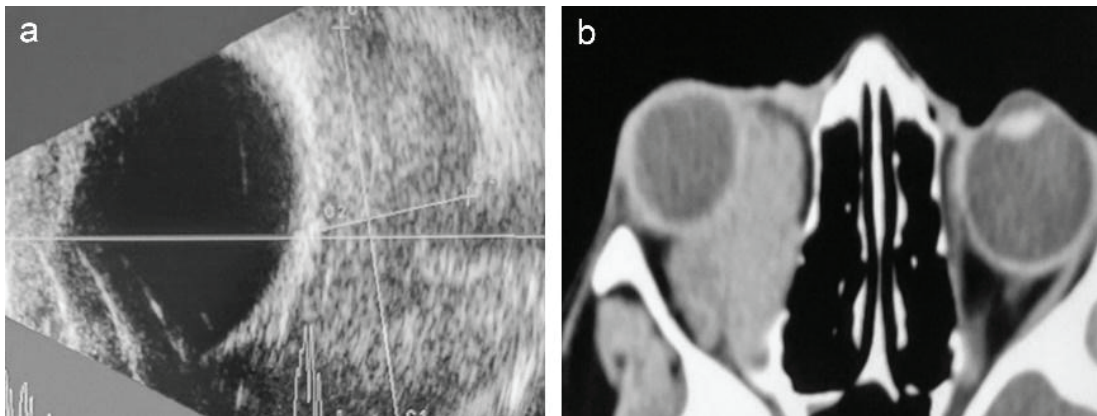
(a) USG-B Scan (b) CT-Scan
